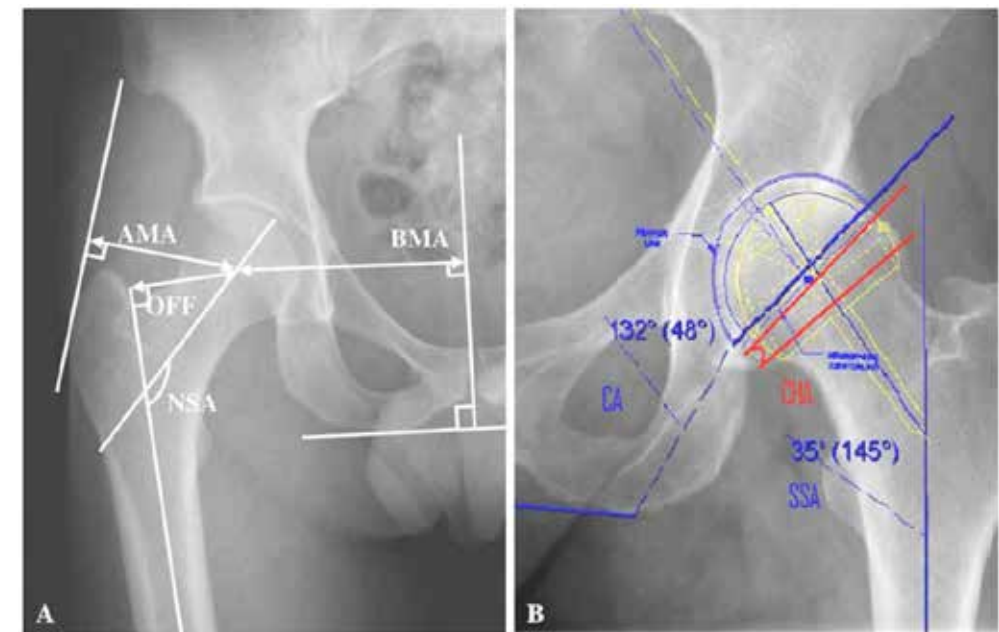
Radiographic measurements on pre-operative X-ray. A Anatomic references for femoral offset, body moment arm (BMA), abductor moment arm (AMA) and neck shaft angle (NSA). B Digital templating for cup angle (CA), stem shaft angle (SSA) and cup head angle (CHA).
